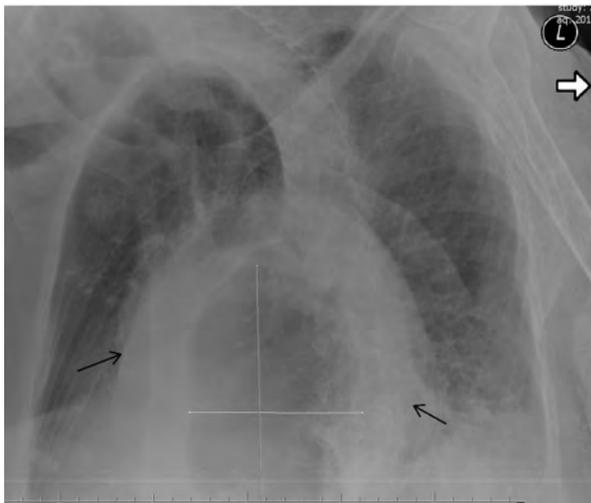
Anterior–posterior chest X-ray. A huge hiatal hernia with translocation of the entire stomach into the chest (black arrows)
